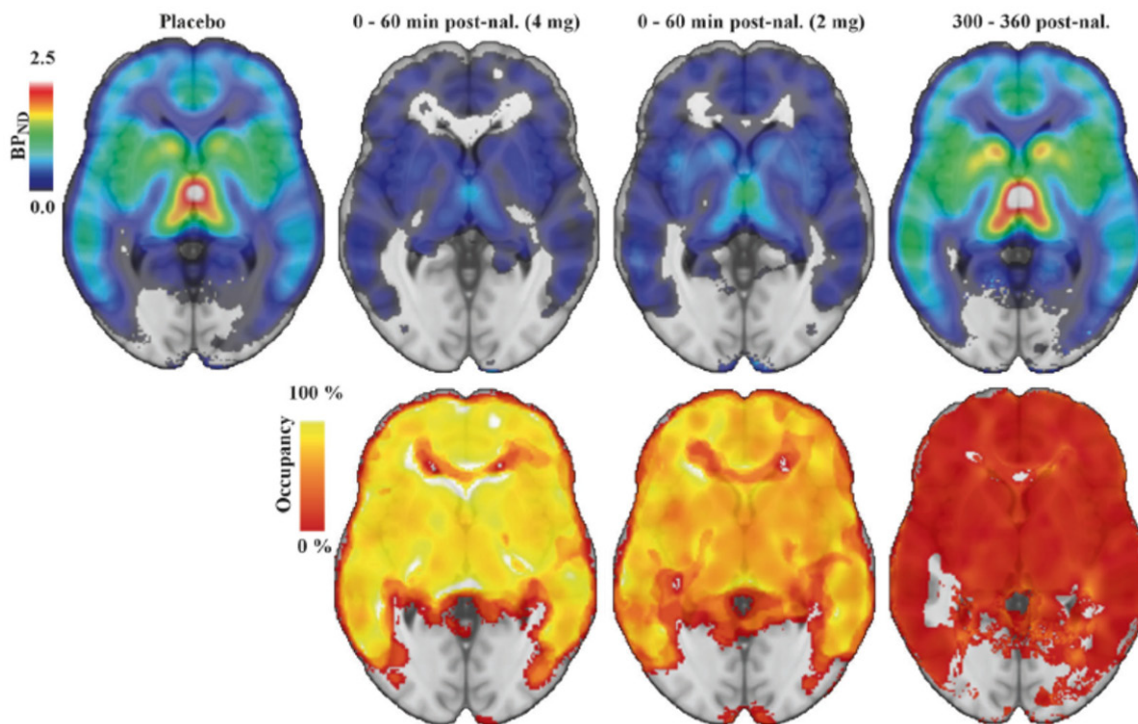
^{11}C -Carfentanil PET imaging of the brain following intranasal naloxone at 0-60 min or 300-600 min. (Adapted from Johansson et al., 2019). ROI-based binding potential was determined using PET imaging of ^{11}C -Carfentanil superimposed on a brain MRI template without naloxone administration (upper left image), at 0-60 min following 4 mg of naloxone (upper second image from left), at 0-60 min following 2 mg naloxone (upper third image from left), or at 300-360 min following 2 or 4 mg naloxone. The bottom row indicates percent occupancy of naloxone relative to placebo at the doses administered in the upper row. BP_{ND} is the binding potential of [^{11}C] carfentanil relative to the uptake of the tracer in the non-displaceable compartment.
